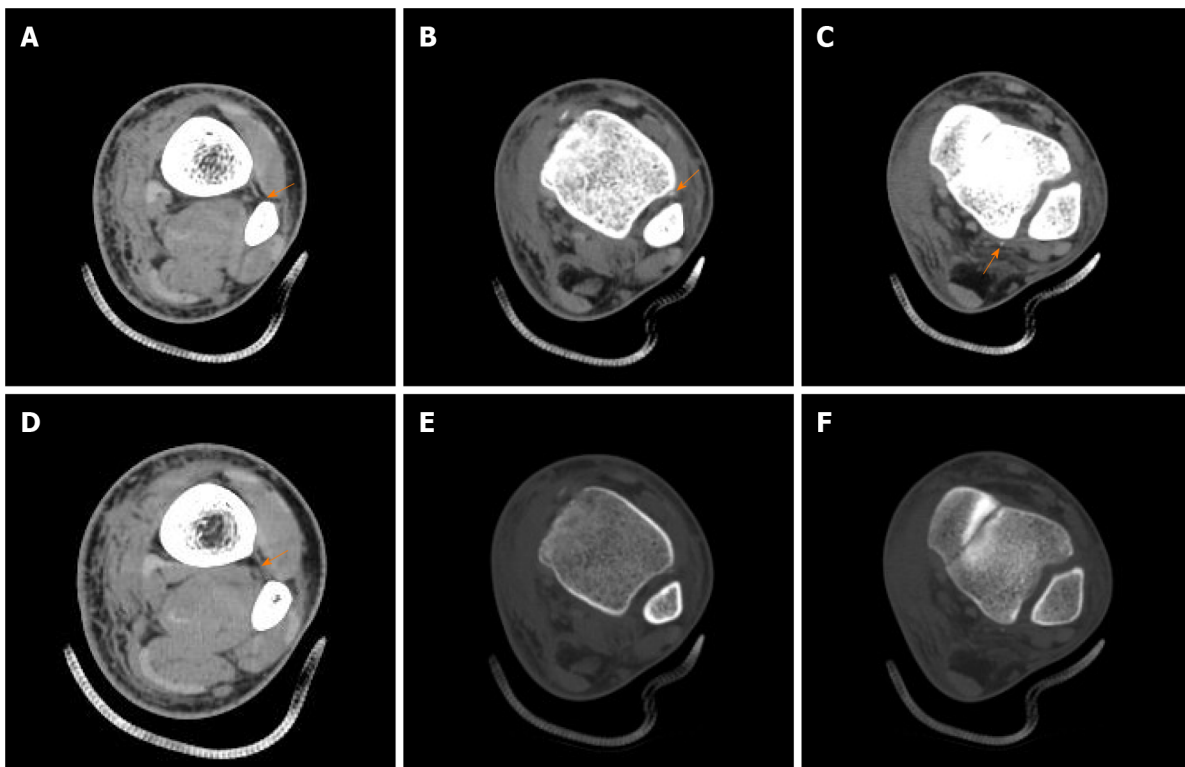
Computed tomography scans indicating complete injury of inferior tibiofibular syndesmosis. A: Rupture of the interosseous membrane (IOM) torn from fibular interosseous crest; B: Avulsion fracture of the anterior inferior tibiofibular ligament (AITFL) in the soft tissue window of computed tomography (CT) scan; C: Avulsion fracture of the posterior inferior tibiofibular ligament (PITFL) in the soft tissue window of CT scan; D: The intact IOM at the proximal part of the calf; E: Avulsion fracture of the AITFL was hardly caught in the bone window of the CT scan (the same B plane); F: Avulsion fracture of the PITFL was hardly caught in the bone window of the CT scan (the same C plane).
